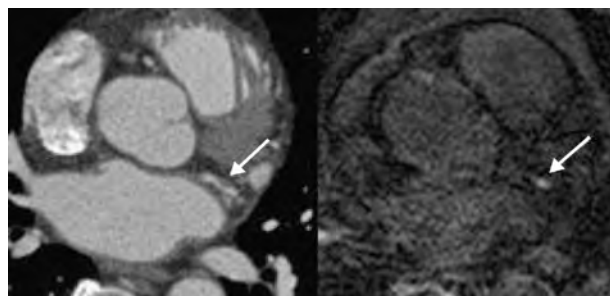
56-year old patient with CAD. CT (left image) demonstrates noncalcified plaque of the circumflex coronary artery. Inversion Recovery MRI (right image) facilitates exclusive plaque visualization.
